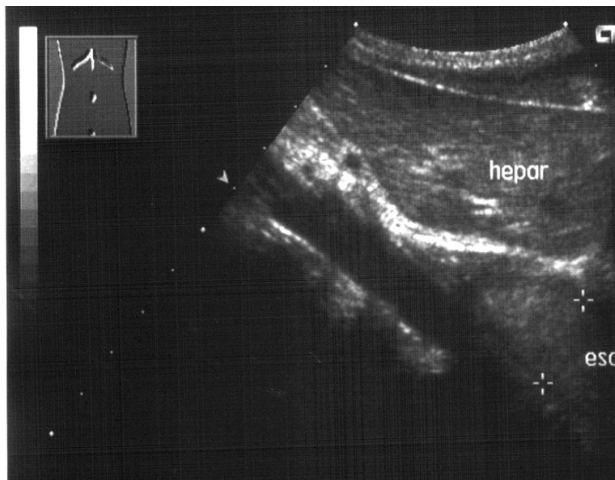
Ultrasonic picture of achalasia of the esophagus
